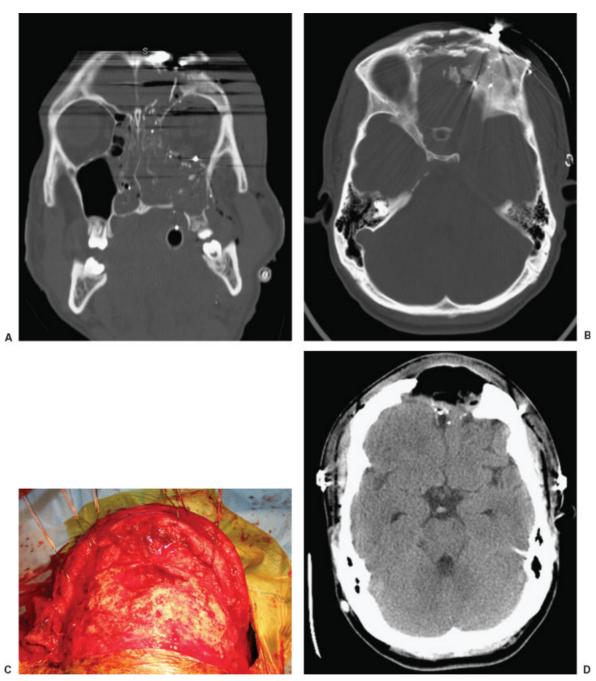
The transbasal approach is well suited for managing anterior skull base trauma. (A) Coronal and (B) axial bone window computed tomography (CT) scans of the head show multiple craniofacial and skull base fractures associated with an open scalp laceration after direct blunt injury. A transbasal approach was used to repair and close the cerebrospinal fluid leak. Due to the increased risk of infection, no orbital bar osteotomies were included. (C) Six months after surgery, the patient underwent surgical débridement of purulent infection with loss of the frontal bone flap, as seen during the procedure and on a (D) postoperative bone window CT of the head. The initial use of the transbasal approach prevented the functionally and cosmetically important orbital bar from being lost to infection.
